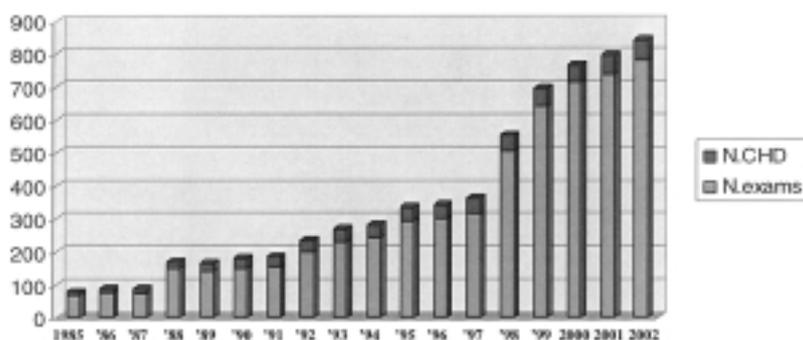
Number of exams (new cases) and of cases with congenital heart disease (CHD) studied at fetal echocardiography per year (1985-2002).
